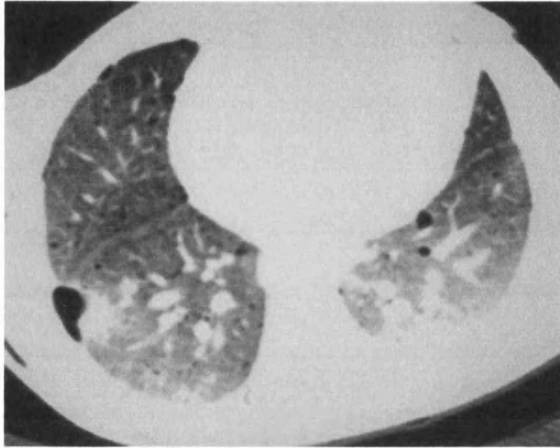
Figure eighteen: HRCT chest of patient with LAM
